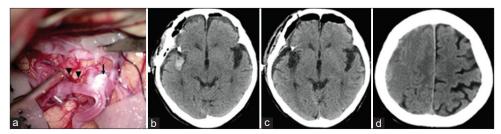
Case 2 (a) During surgical clipping for an aneurysm (arrow) of the right middle cerebral artery, a thin and pial artery bleeds slightly at 2 points of the right temporal lobe (arrowheads), and hemostasis is easily achieved using cotton. (b) Computed tomography (CT) 19 h after surgery shows no evidence of intracranial hemorrhage. (c) CT 94 h after restarting dabigatran shows subarachnoid hemorrhage in the right Sylvian fissure. (d) CT 864 h after surgery shows a right chronic subdural hematoma.
